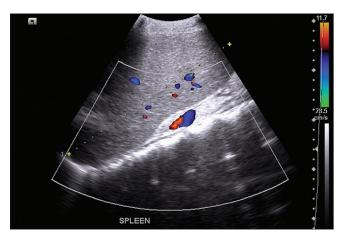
Ultrasound examination, showing in longitudinal reconstruction, a homogeneous splenomegaly
